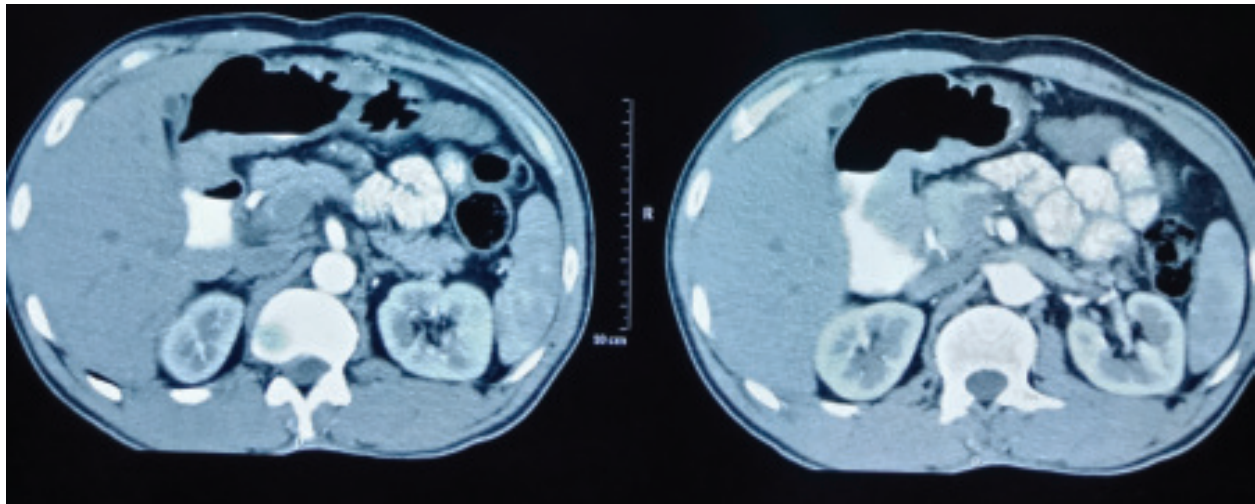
CT Abdomen of Carcinoma stomach with Pancreatic metastasis
